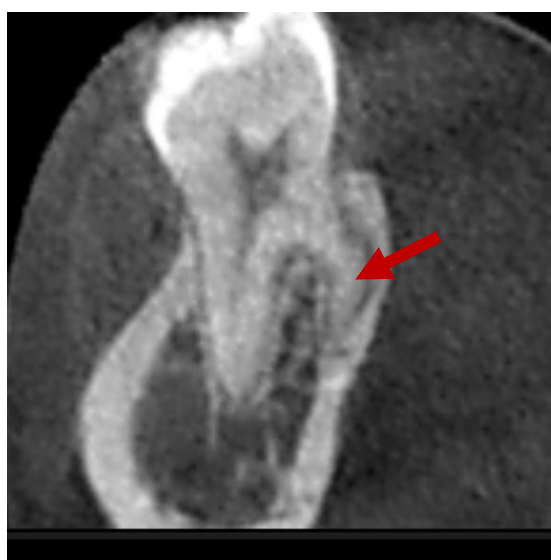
Sagittal view of cone-beam computed tomography image of mandibular molar with radix entomolaris. Red arrow showing slender and acute root curvature.
